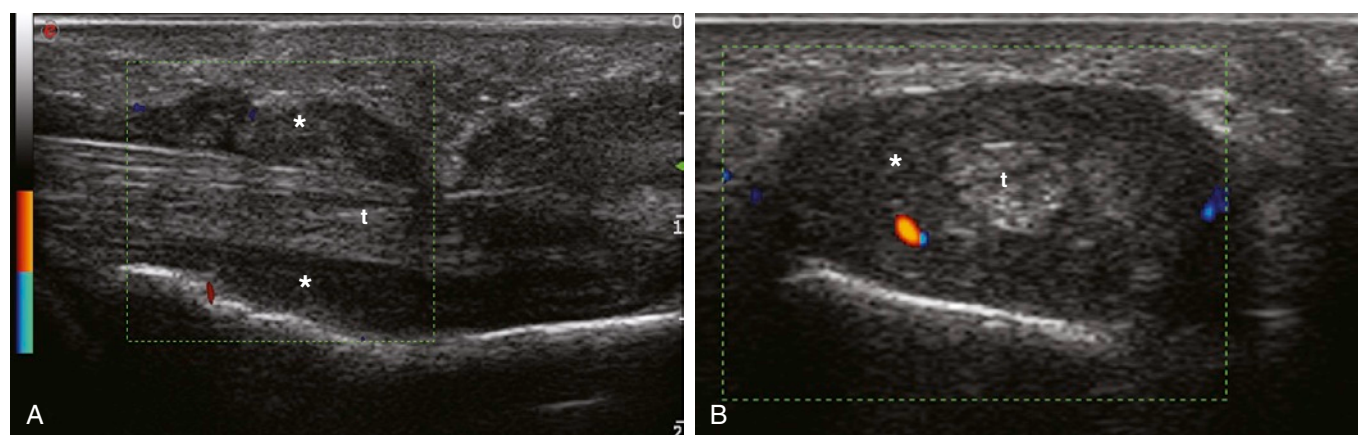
Tenosynovitis (*stars*) of the flexor digitorum tendon (t) is seen with power Doppler activity on longitudinal (A) and transverse (B) views.
